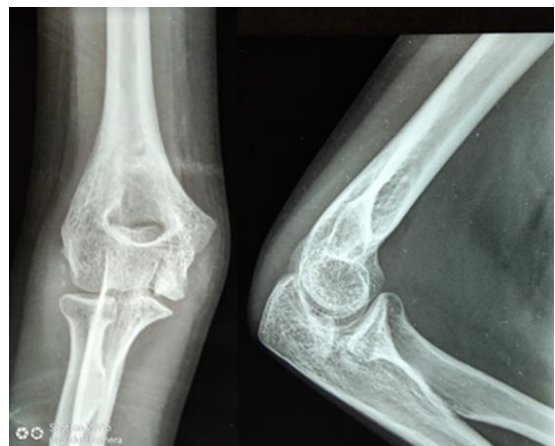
Repeat x-ray showing avulsion fracture of medial epicondyle.
